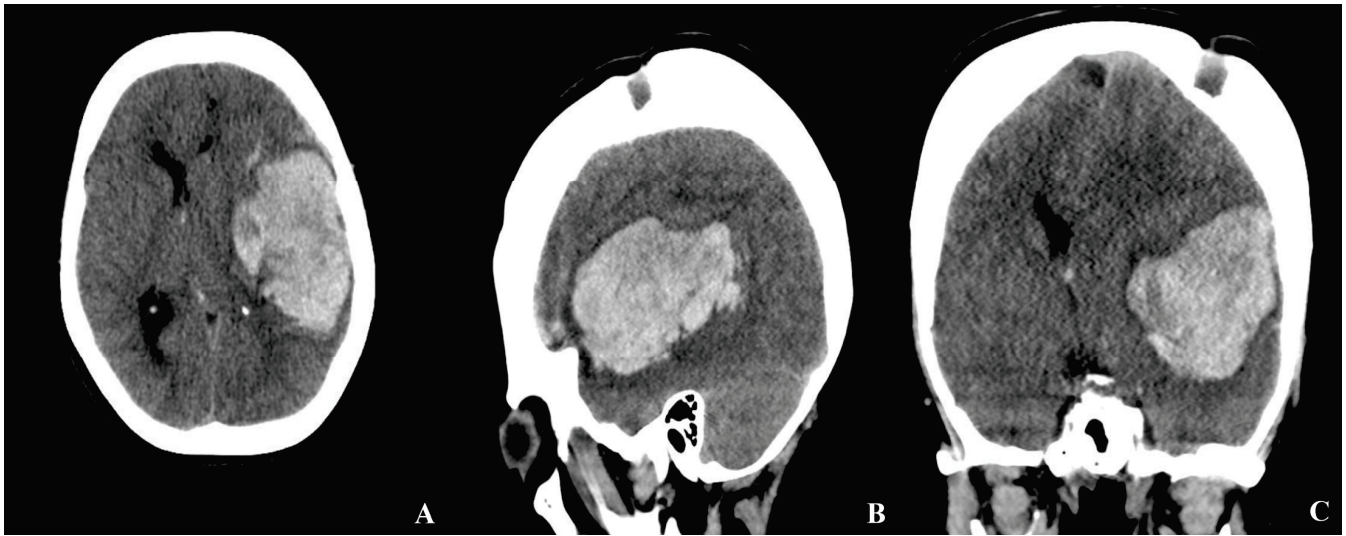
Initial brain CT obtained at the patient's presentation to the emergency department ((A) axial, (B) sagittal, (C) coronal view). The scan demonstrates a large intraparenchymal hematoma in the left temporal and insular lobes, accompanied by a significant midline shift to the right and mass effect with compression of the adjacent ventricular structures. Multiple burr hole defects from the previous revascularization procedure are also visible.
